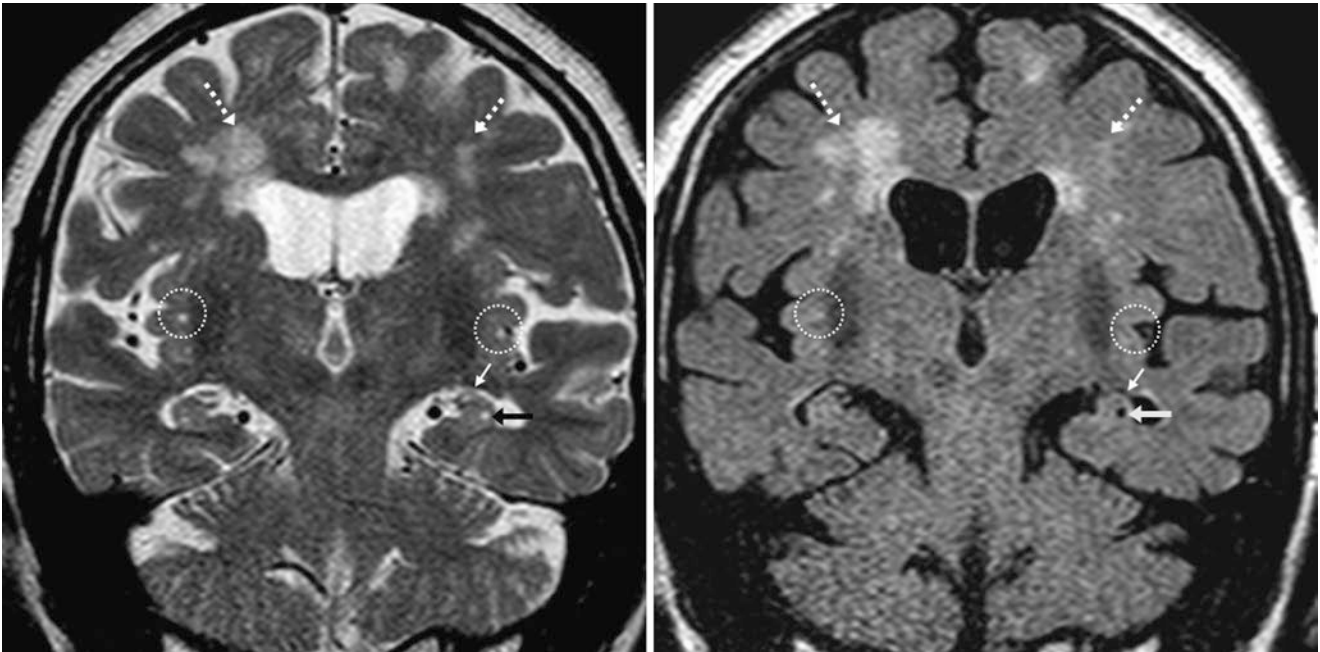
Testing of a 71 year old with coronal T2WI (*left*) and FLAIR (*right*) MR images revealed a small left hippocampal cyst (*arrows*) just inferior to the choroidal fissure (*thin arrows*). There are also incidental slightly dilated PVs within the subsular white matter bilaterally
